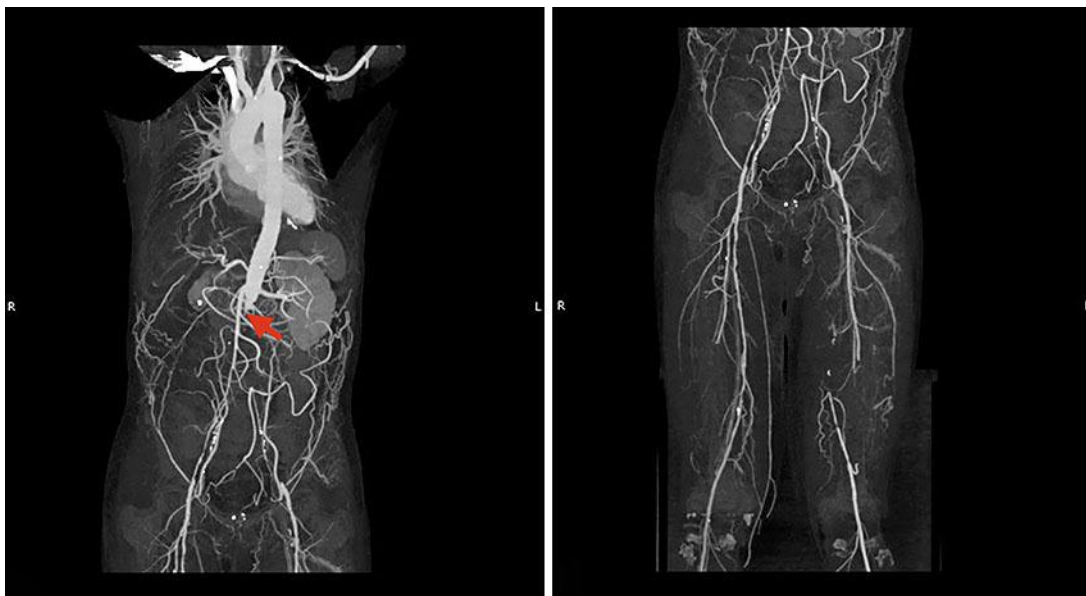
Computed tomography angiography showing total occlusion of the right infrarenal aorta extending to the aortic bifurcation (arrow), both common iliac arteries and the internal and external iliac arteries.
